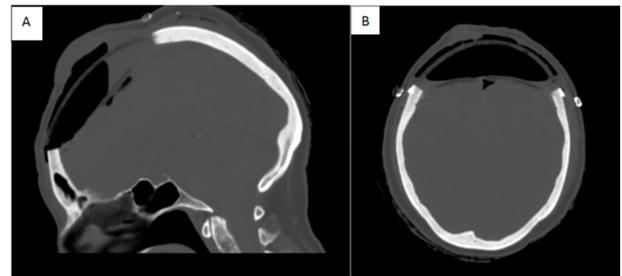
Post operative CT-scan, sagittal (A) and coronal (B).
